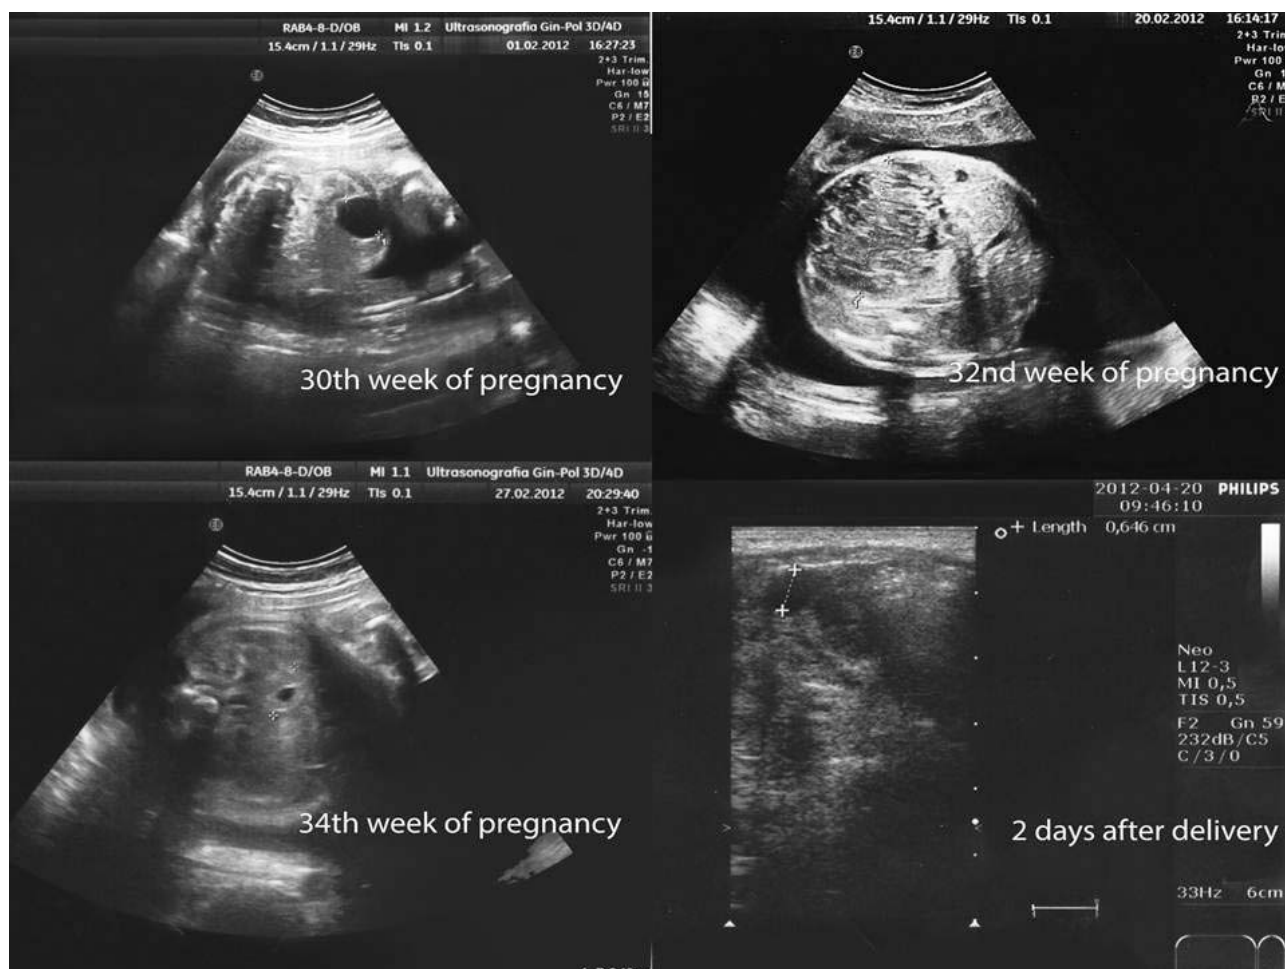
Ultrasonographic pattern of spontaneous resolving fetal ovarian cyst.
